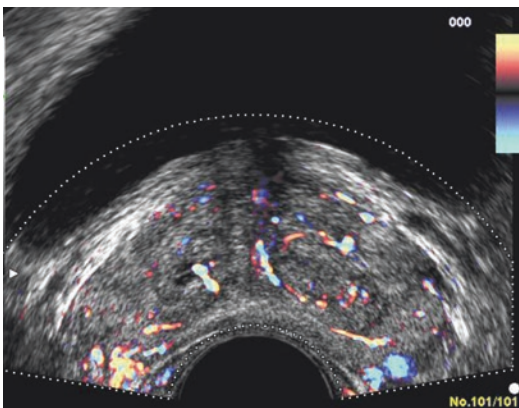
More intense Doppler signals are observable proximally to neurovascular bundles and in the peri-capsular and periprostatic zone
